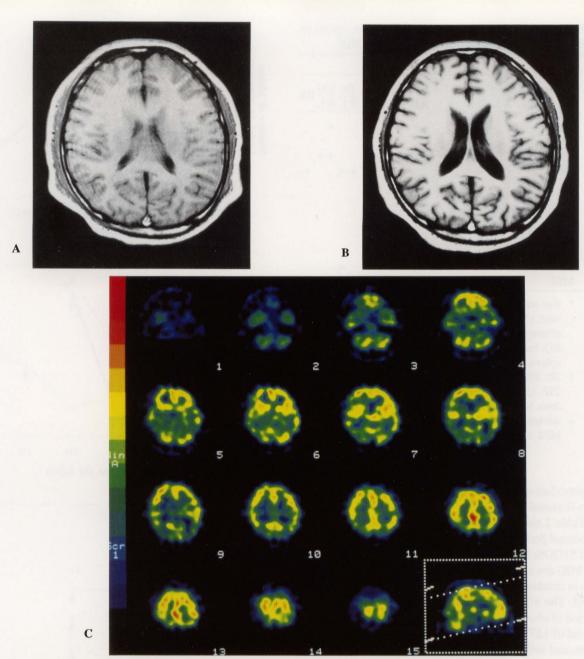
MRI (T<sub>1</sub>-weighted images) and SPECT images of a typical case (No. 3) (MRI: 1 wk (A) and 1 mo (B) after the injury, SPECT (C): 1 mo after the injury). There is no diffuse brain atrophy on MRI after 1 wk (A). Diffuse brain atrophy is observed after 1 mo (B). Widespread hypoperfusion is observed on SPECT including in non-depicted regions on MRI (C). In all images, the anterior is at the top of the image and the subject's right is on the left.
